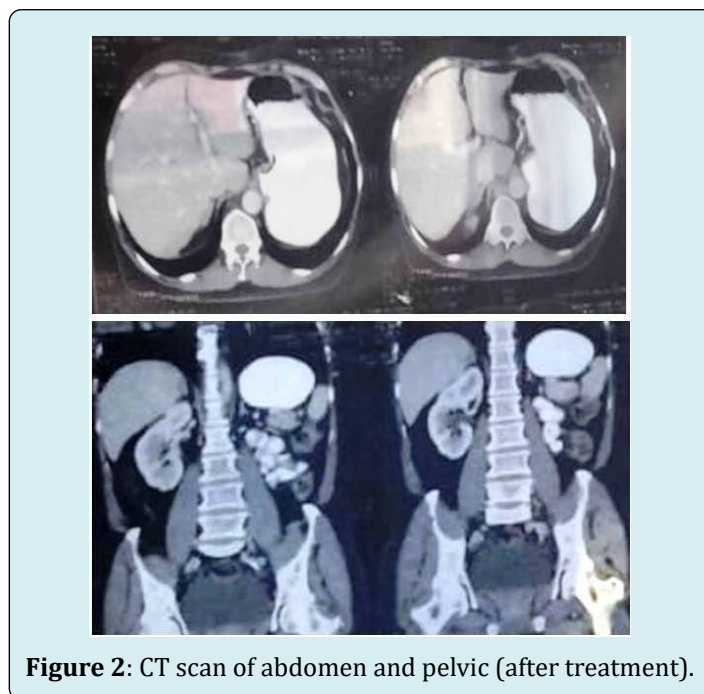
CT scan of abdomen and pelvis (after treatment).
